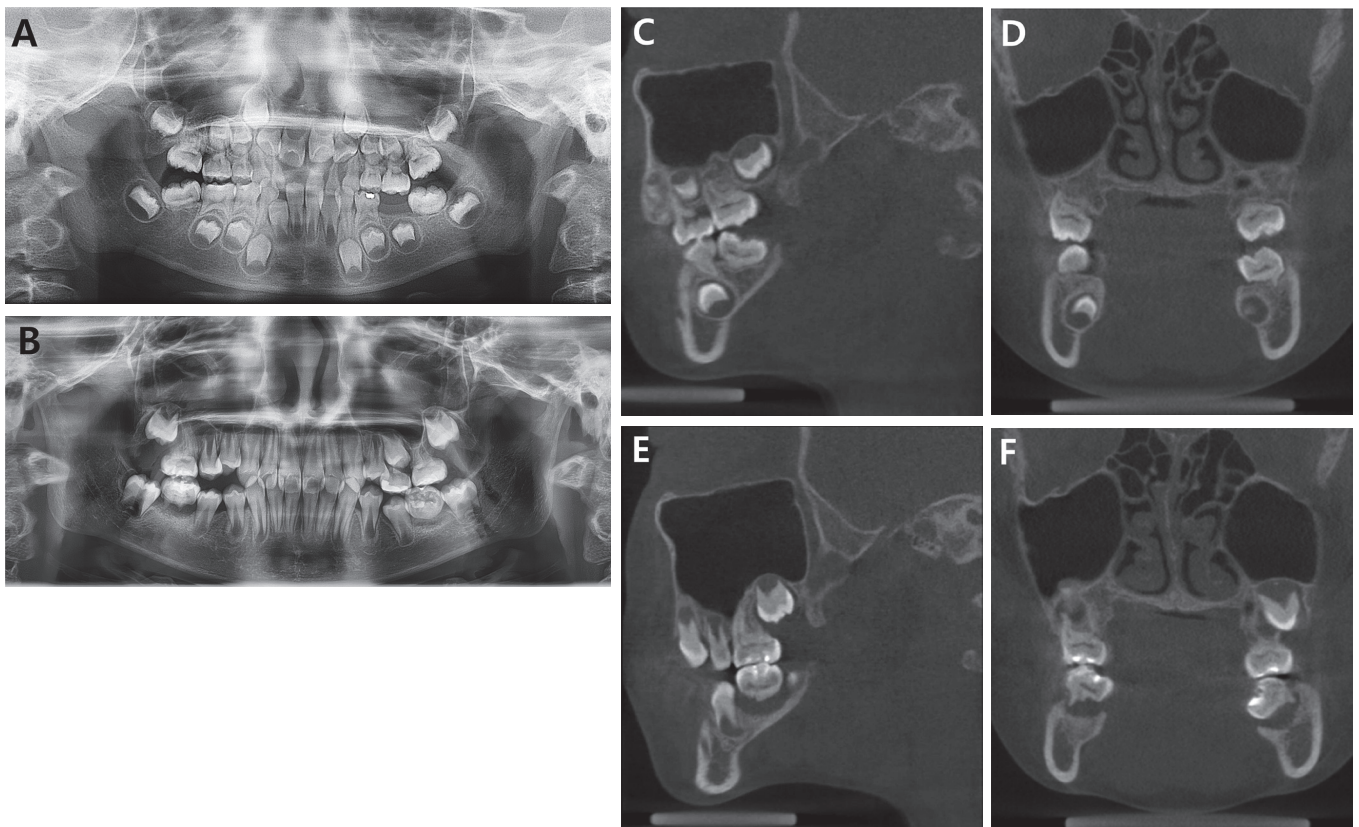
Radiographs of patient 1. (A) Initial panoramic view. (B) Panoramic view at 3.5 years after first visit. (C, D) Initial cone-beam computed tomography images of the patient. The root of the left maxillary permanent first molar at around 6 years of age appeared to be short, with an open apex. (E, F) At 3.5 years after first visit, the maxillary first molar had not only erupted but also developed roots and apical closure. Inflammatory bone resorption in the mandibular permanent first molars was progressed.
